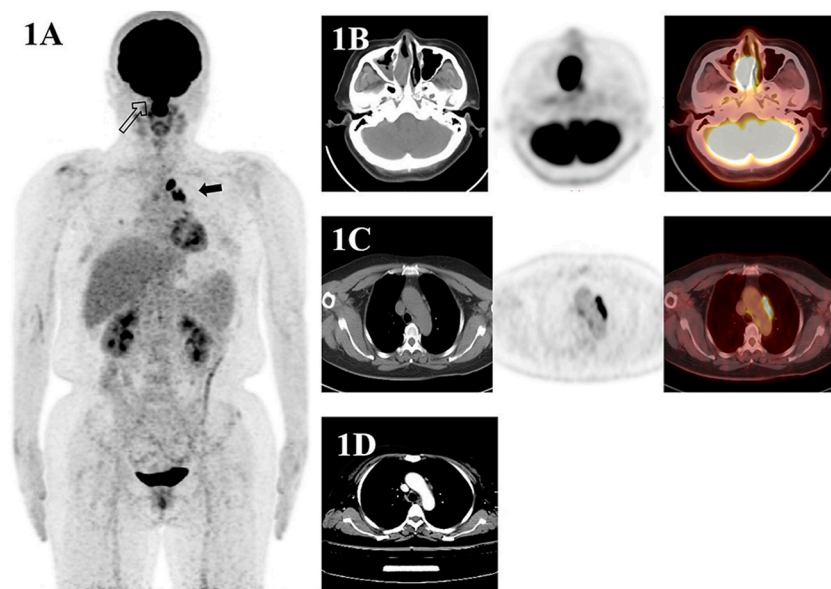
A 54-year-old woman with newly diagnosed nasal-type NK/T-cell lymphoma underwent ¹⁸F-FDG PET/CT scan (A–C) and enhanced CT scan (D) for initial staging. Maximum-intensity-projection image (A) shows hypermetabolic lesions in right ethmoid sinus (empty arrow), mediastinal lymph nodes (arrow). Transaxial images of ¹⁸F-FDG PET/CT scan shows ¹⁸F-FDG-avid mass in right ethmoid sinus (B). ¹⁸F-FDG PET/CT scan shows intense ¹⁸F-FDG uptake in mediastinal lymph nodes, suggesting malignancy (C). However, enhanced CT scan shows only small lymph nodes with less than 1 cm of short-axis diameter in mediastinal, which is not consistent with malignancy (D). Finally, after PET/CT scan is obtained, staging is changed from I to II. After 4 cycles of chemotherapy, follow-up ¹⁸F-FDG PET/CT scan shows normalized ¹⁸F-FDG uptake mediastinal lymph nodes.
